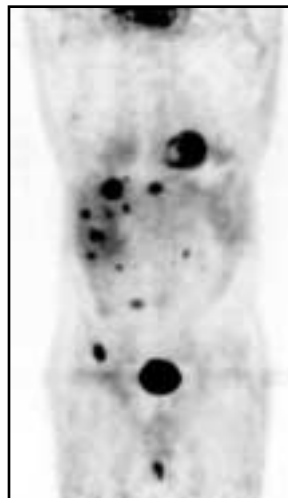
FDG whole-body PET. Recurrent colorectal cancer with multiple extensive metastases on FDG-PET to both lobes of the liver, mesenteric nodes, and right iliac crest.
